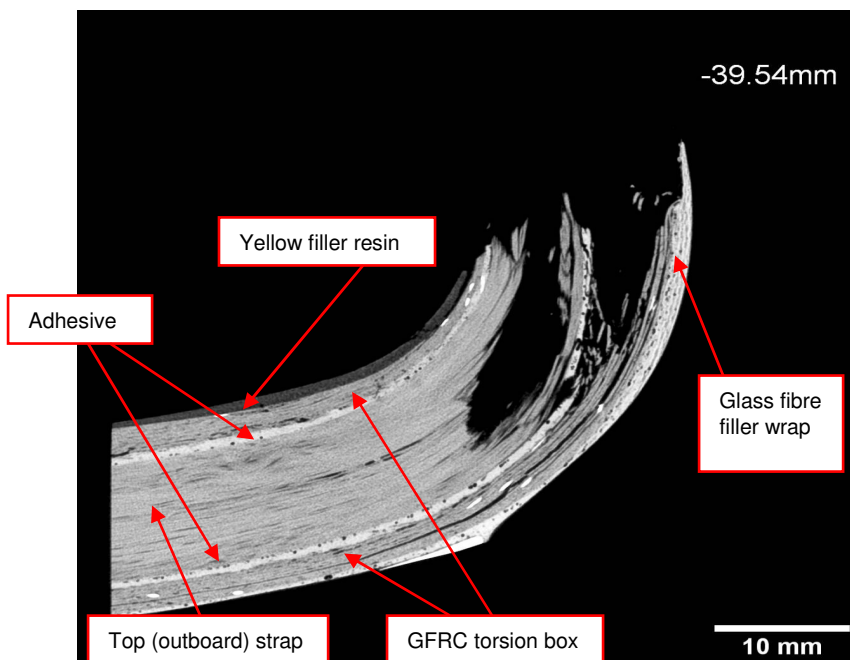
X-ray tomography image showing side-view slice through the top (outboard) strap of the White blade, trailing edge fracture location, approximately 4 mm from the outboard edge of the blade arm
